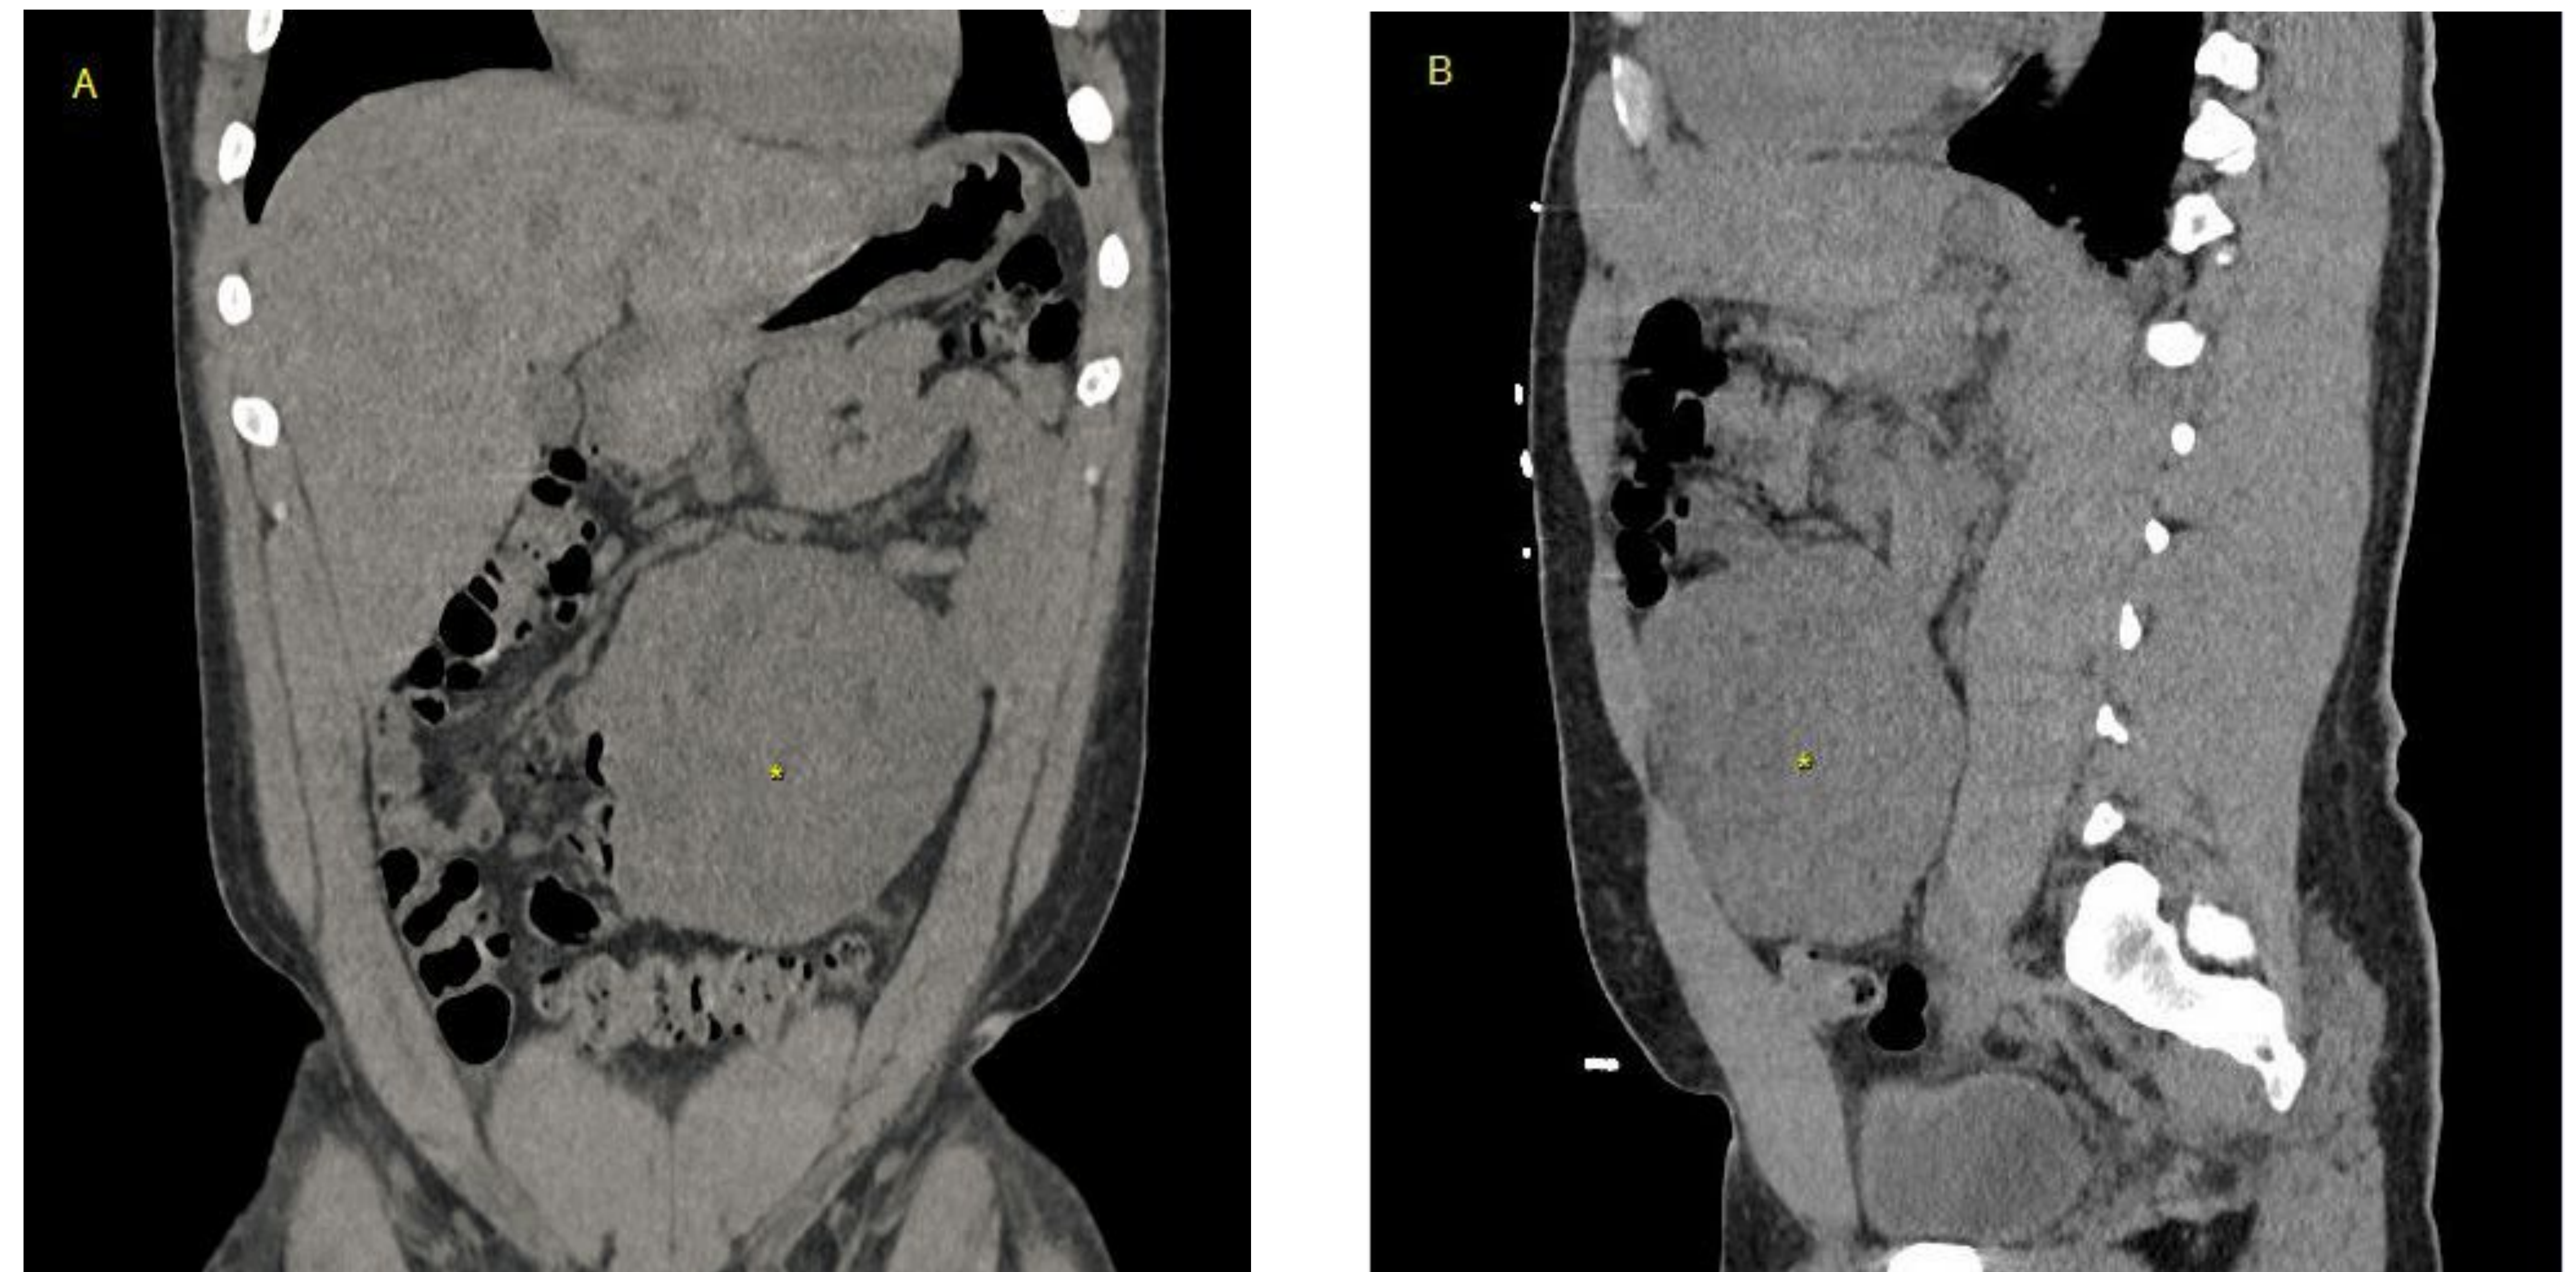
Computed tomography scan images of abdomen showing the 15 cm x 13.5 cm x 8 cm leiomyoma in a coronal view (A) and sagittal view (B).
